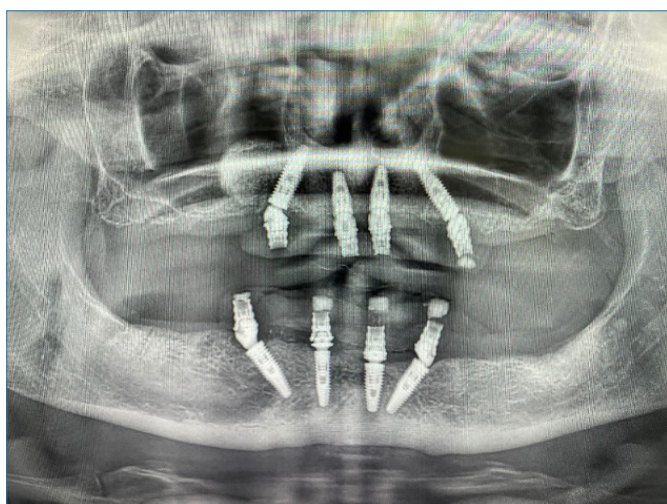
Orthopantomographic image of the patient after implant application with All-on-4 concept
